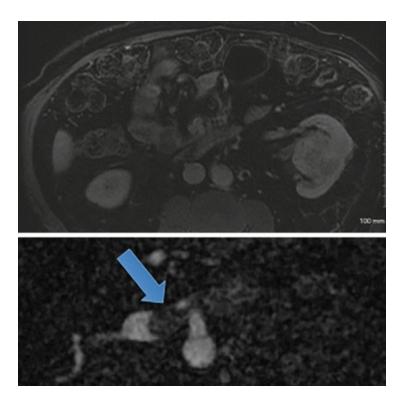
Contrast-enhanced MRI demonstrates heterogenously enhancing left renal cell carcinoma with expansion of the left renal vein and inferior vena cava with tumor thrombus (arrow)
